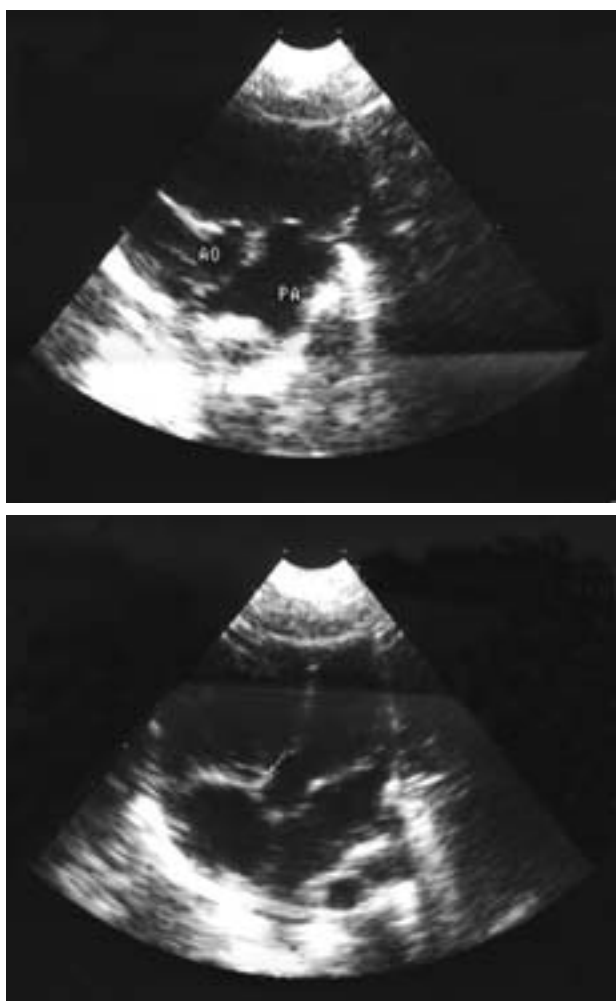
Echocardiography showed a small atrial septal defect, a moderate ventricular septal defect, and increased pressure of the pulmonary artery.
